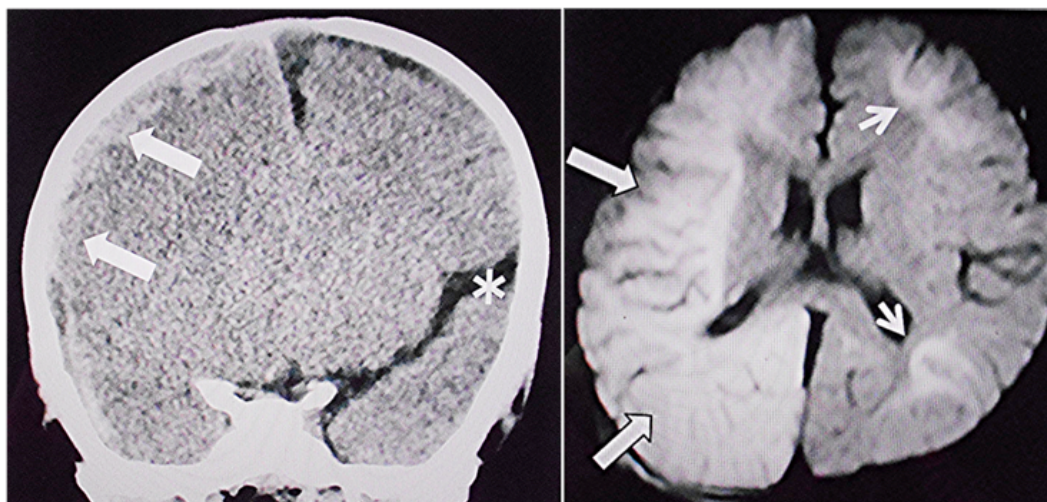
Case 2 (No.8), male aged 8 months. Left: Coronal CT at one hour after onset showing a mixed-density, acute subdural hematoma with a mass effect on the right side. (arrows) Note the large sylvian fissure on the left side. (asterisk). Right: Diffusion Weighted (DW) MRI on postoperative day 2 demonstrating a bright tree appearance with remarkably high intensity in the white matter in the entire right cerebral hemisphere (arrows) and part of the left cerebral hemisphere. (small arrows) This phenomenon, known as a traumatic brain injury with a biphasic clinical course and late reduced diffusion, may have been caused by delayed surgery coupled with postoperative poor seizure control. Note the resolution of the midline shift.
